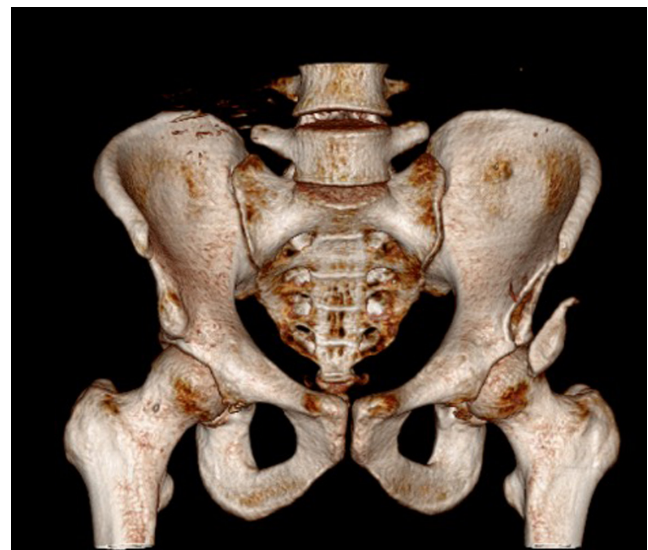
Preoperative 3D computed tomography scan shows fracture configuration.
